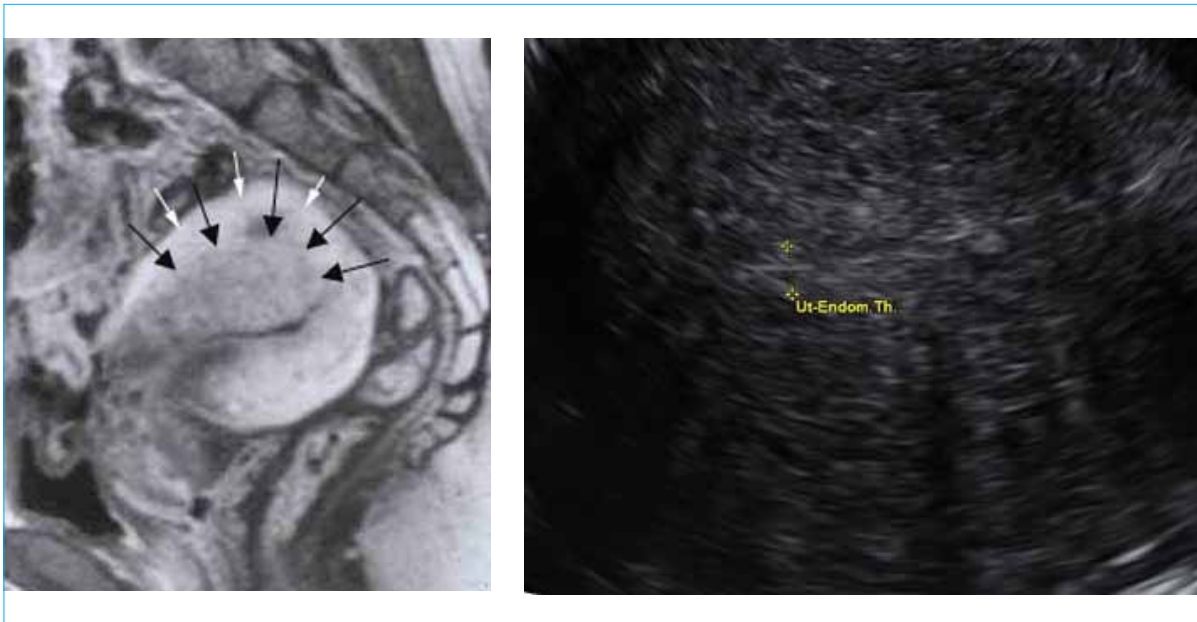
Left MRI, Right: Ultrasound images for adenomyosis
